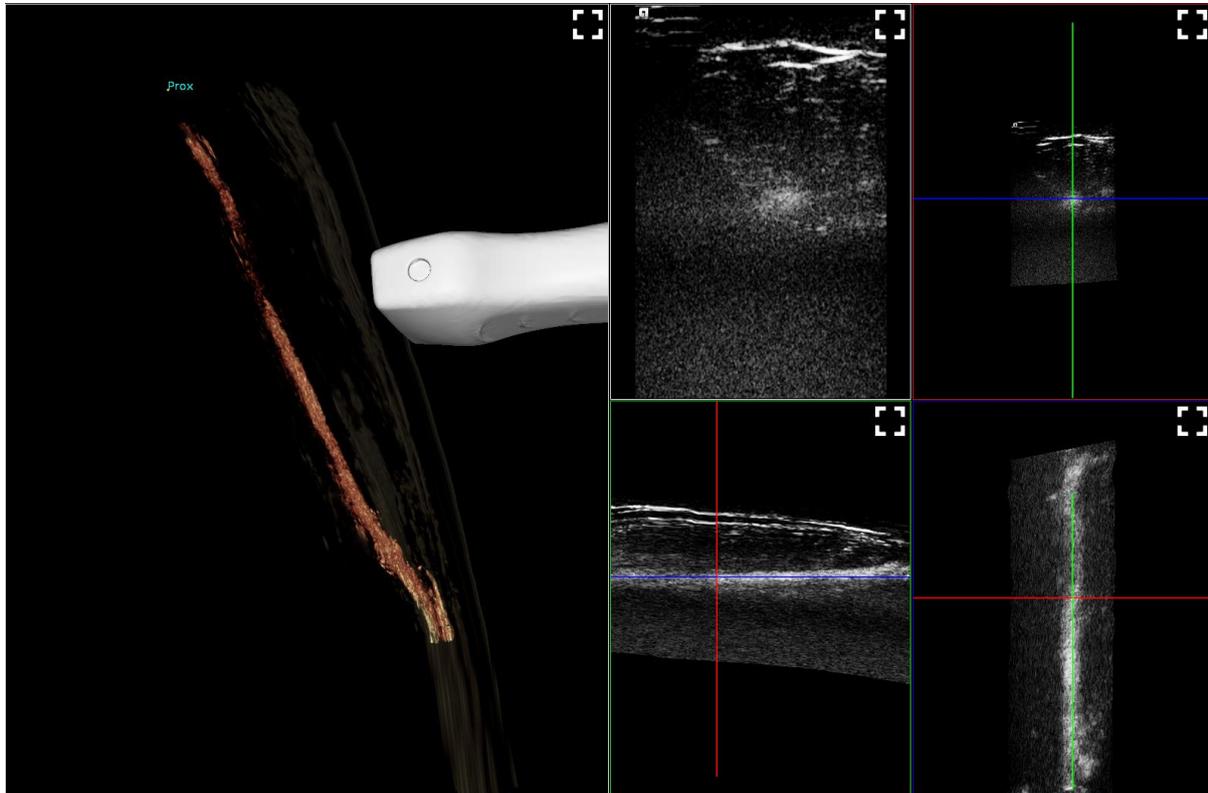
Tomographic ultrasound angiogram of ATA showing widely patent good calibre vessel throughout
